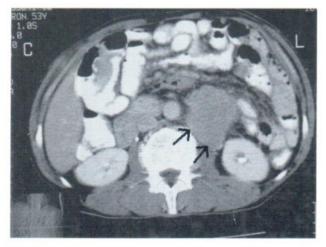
The CT section caudad to 2B showed a homogeneous retroperitoneal soft tissue mass located between the lower pole of left kidney and aorta (arrows).
